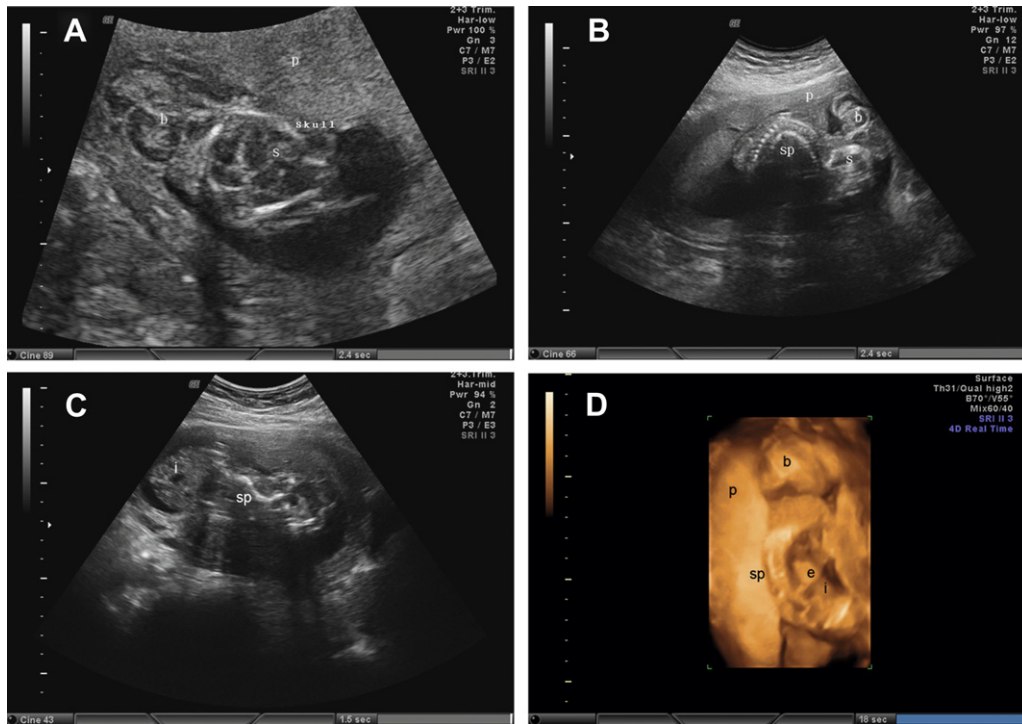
(A) A deformed skull with acranium and attachment of the brain to the placenta. (B) Scoliosis with a curved spine and craniofacial deformation with acranium, a small skull, and attachment of the brain to the placenta. (C) Extracorporeal intestines and a deformed spine. (D) Corresponding three-dimensional ultrasound shows a curved spine, extracorporeal liver and intestines, and attachment of the brain to the placenta. b = brain, i = intestines, l = liver, p = placenta, s = skull, sp = spine.
